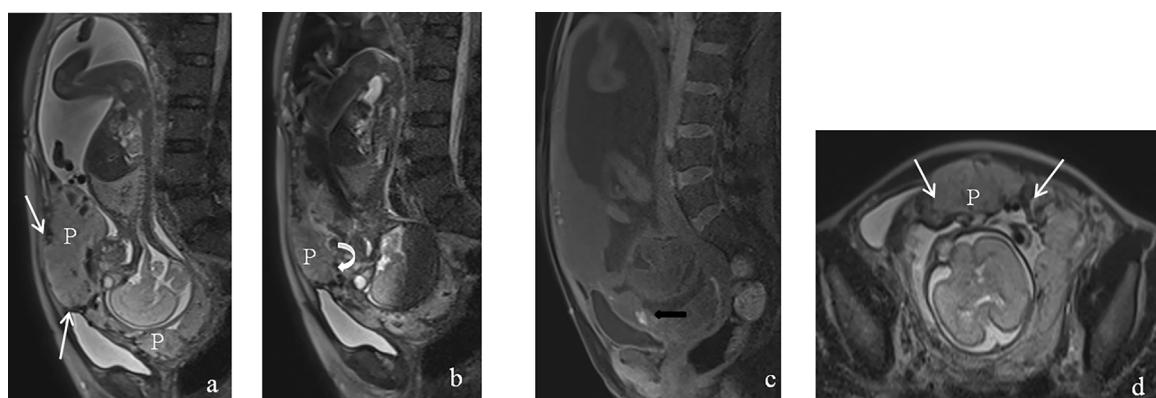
PP and percreta.- 26 y.o. patient with 1 prior cesarean delivery and status post dilation and curettage. Sagittal T2-W (a, b), sagittal T1-W (c) and axial (d) T2-W MR images at the 24th week of pregnancy show a placenta previa (P), markedly heterogeneous, with multiple intraplacental dark bands (curved arrows, b) and hematic rests, hyperintense on T1-W imaging (c). Note prominent anomalous uterine contour with uterine “bulging” and absence of clear identification of the myometrium between the white arrows in a and d. The patient developed acute severe vaginal bleeding and abdominal pain 24 h after MR exam. Emergency surgery discovered uterine rupture at the old cesarean scar level with partial protrusion of the placenta. The fetus died and hysterectomy was required.
